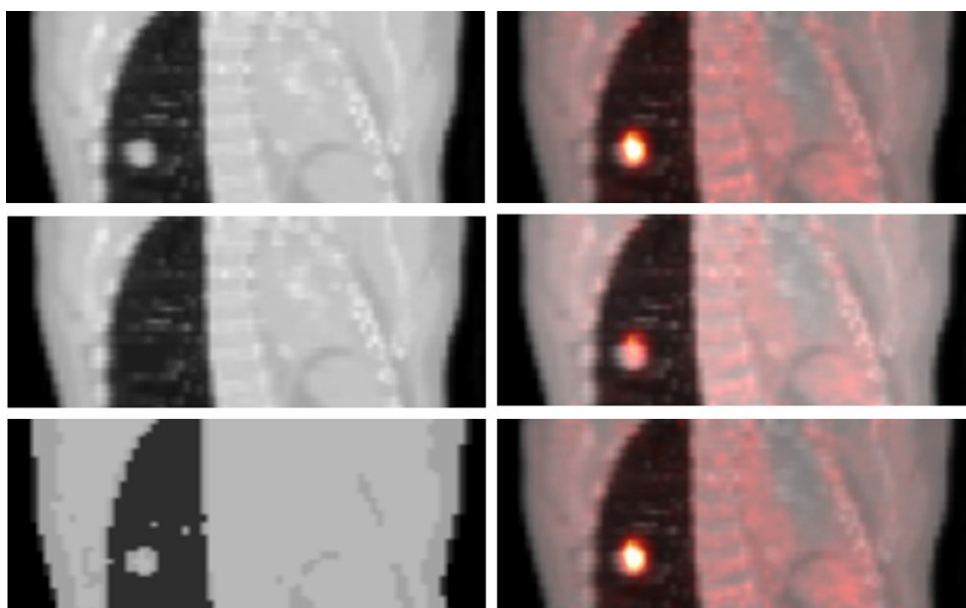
Patient with a tumor in the right lung and a pulmonary edema in the left lung. Attenuation maps used for the reconstruction (left), and reconstructed PET image fused to the original CT (right) are shown. Upper row: original CT-based attenuation map. Middle row: CT-based attenuation map with lung tumor manually removed from the map. Bottom row: segmented attenuation map. While the segmented attenuation map results in a ΔSUV of +1.6%, the deletion of the lung tumor results in a ΔSUV of -35%, indicating potential pitfalls for atlas based approaches. Image reprinted by permission of the Society of Nuclear Medicine from [184].
